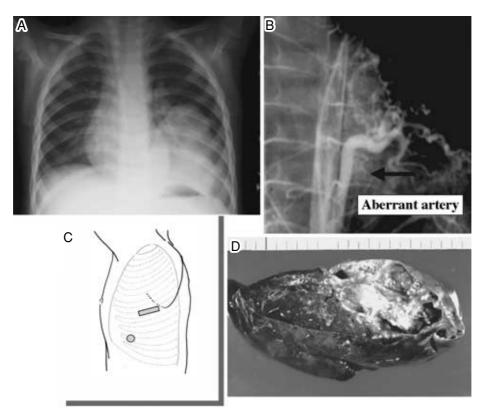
Patient 4. Intralobar pulmonary sequestration A, preoperative chest radiography; B, preoperative angiography of aberrant artery from abdominal aorta; C, position of minithoracotomy and trocar port; D, sequestrated lung tissue in resected lower lobe.
